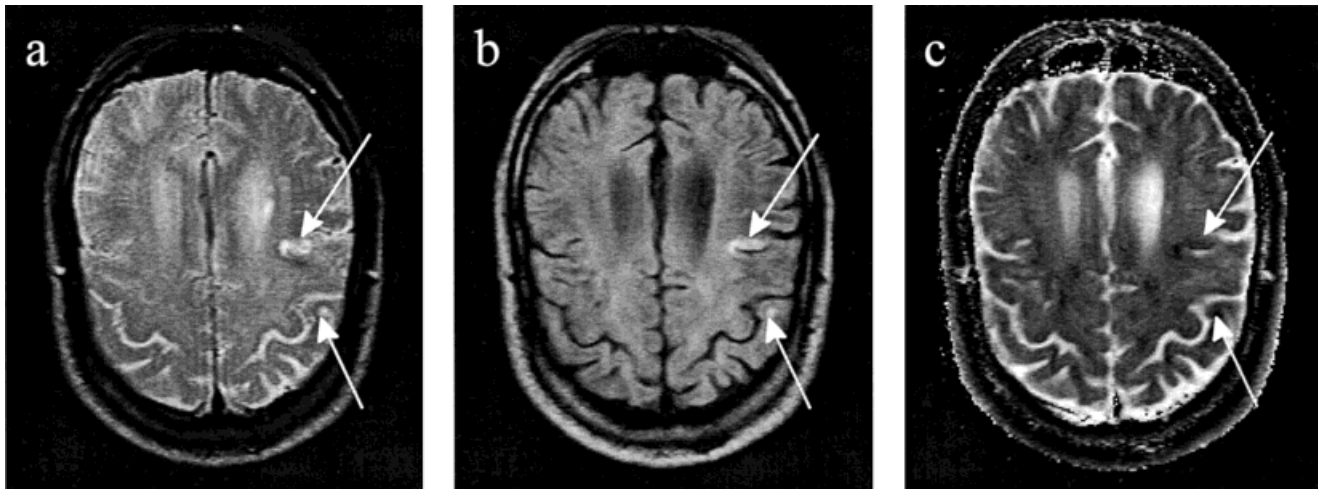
T₂w image (a), DWI (b, b -factor = 529 sec/mm²), and ADC map (c) at a second slice position of the patient shown in Fig. 5. In a, the lesions (arrows) can hardly be differentiated from adjacent structures with high T₂w SI intensities (CSF). The high spatial resolution of navigated spin-echo DWI allows a clear differentiation of even small ischemic regions (b, arrow) exhibiting a reduced mean ADC value of about 60% that of normal values.
